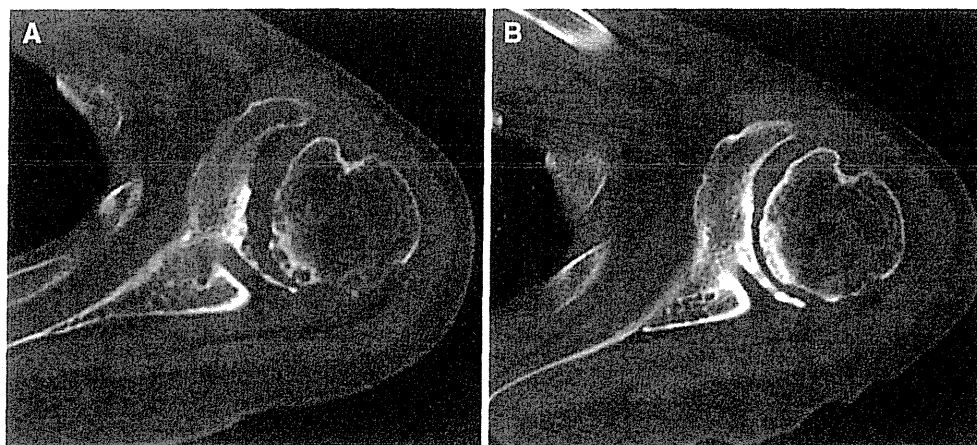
Horizontal and coronal views of computed tomography (CT) scan of left shoulder joint at baseline (a) and at final follow up (b)
